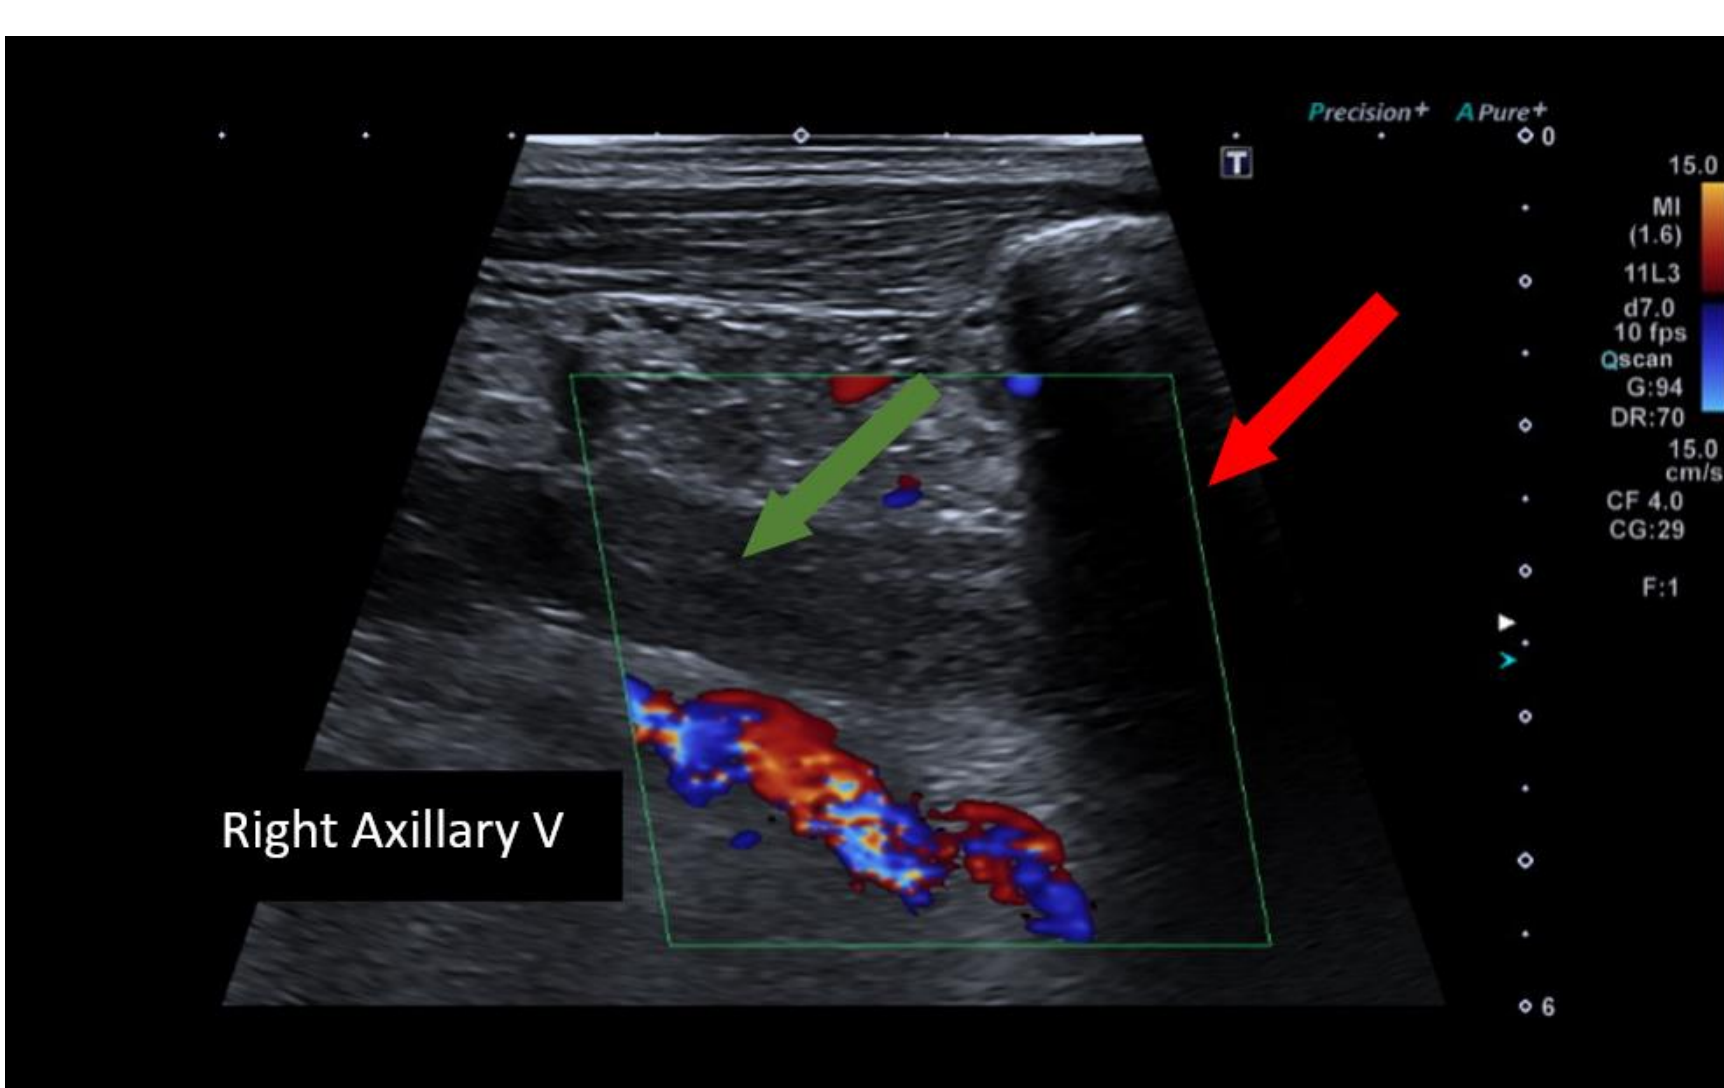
A Duplex (B-mode and colour Doppler) longitudinal image of the right axillary vein (green arrow). There is mixed echogenicity thrombus within and a complete absence of blood flow to the vein. Red arrow indicates posterior shadowing from the clavicle bone. (Hospital "X", 2023).
